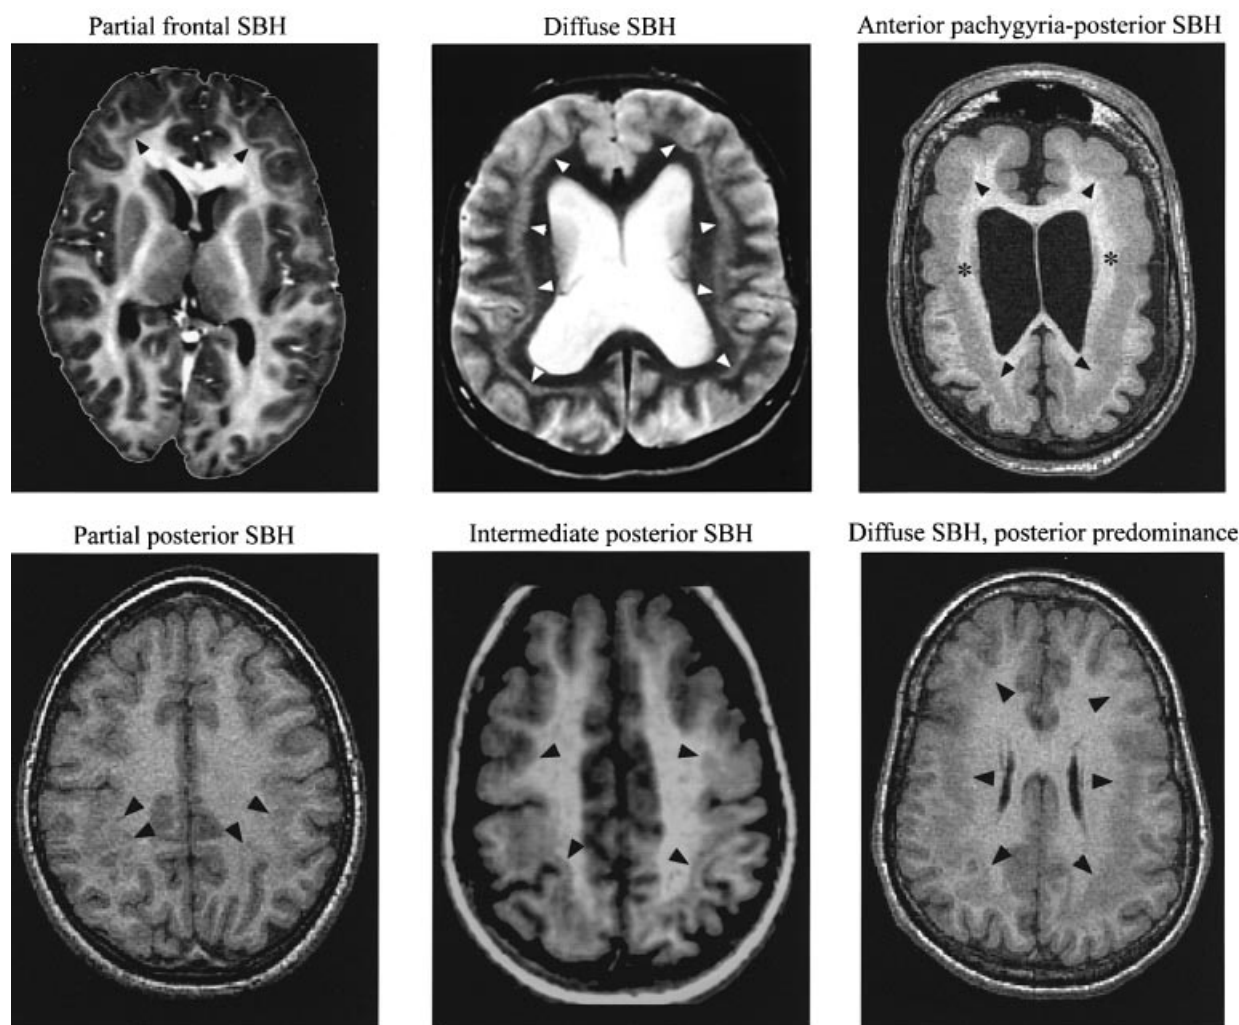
Brain MRI axial cuts from six patients included in this study. Pictures are representative of SBH subtypes. The arrows indicate the location and extent of the SBH and pachygyria. In the anterior pachygyria-posterior SBH pattern, asterisks indicate the point where posterior SBH merges with anterior pachygyria.
